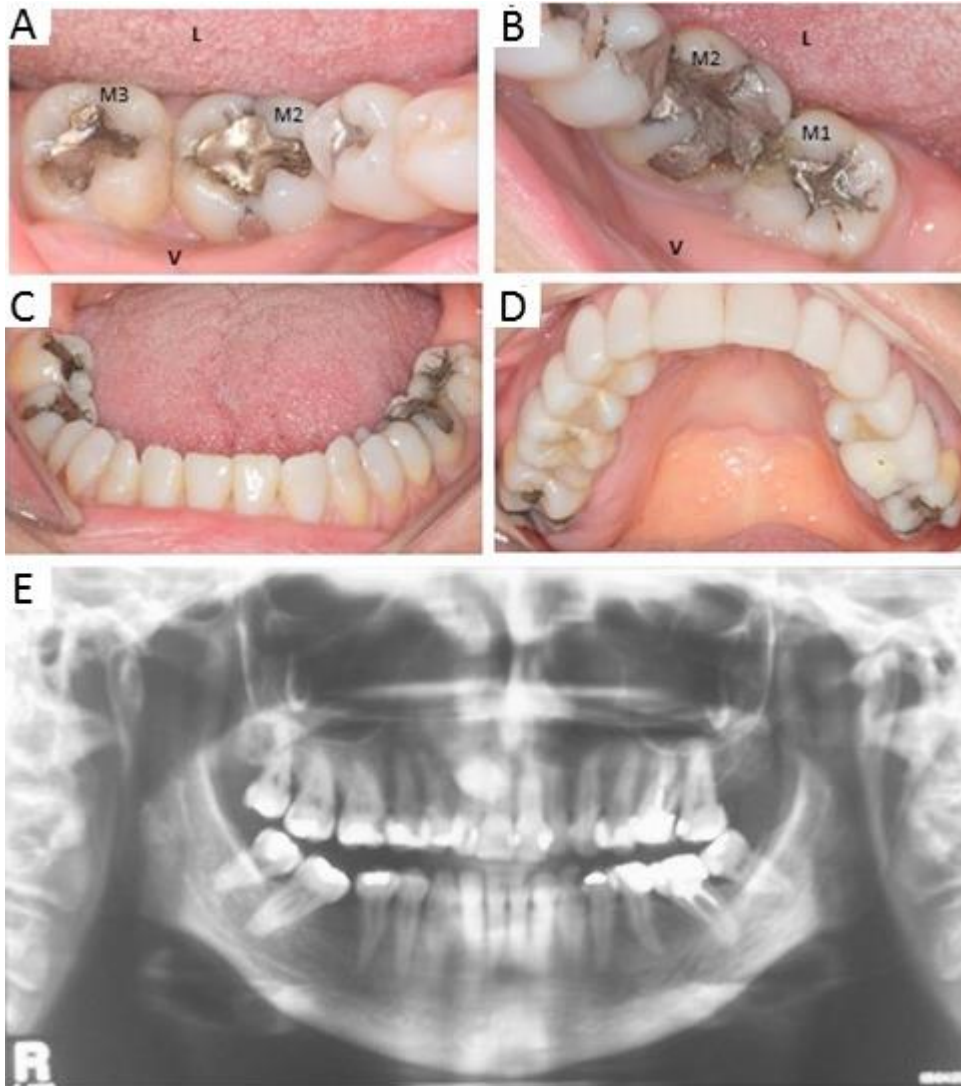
(Patient 2): a) Occlusal view of the right mandibular molars and showing the absence of first mandibular right molar. b) Tooth transposition between first and second left mandibular molars. c) Mandibular arch view. d) Maxillary arch view. e) Panoramic Radiography.
